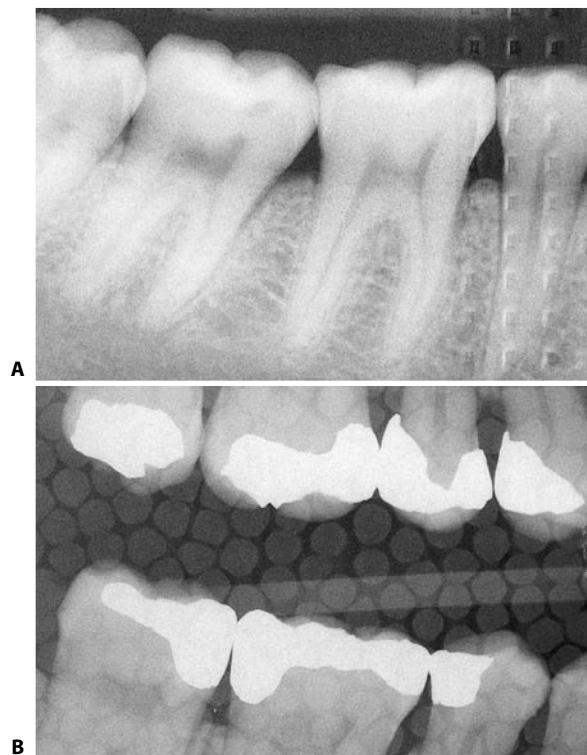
The radiograph has been placed back to front in mouth.
